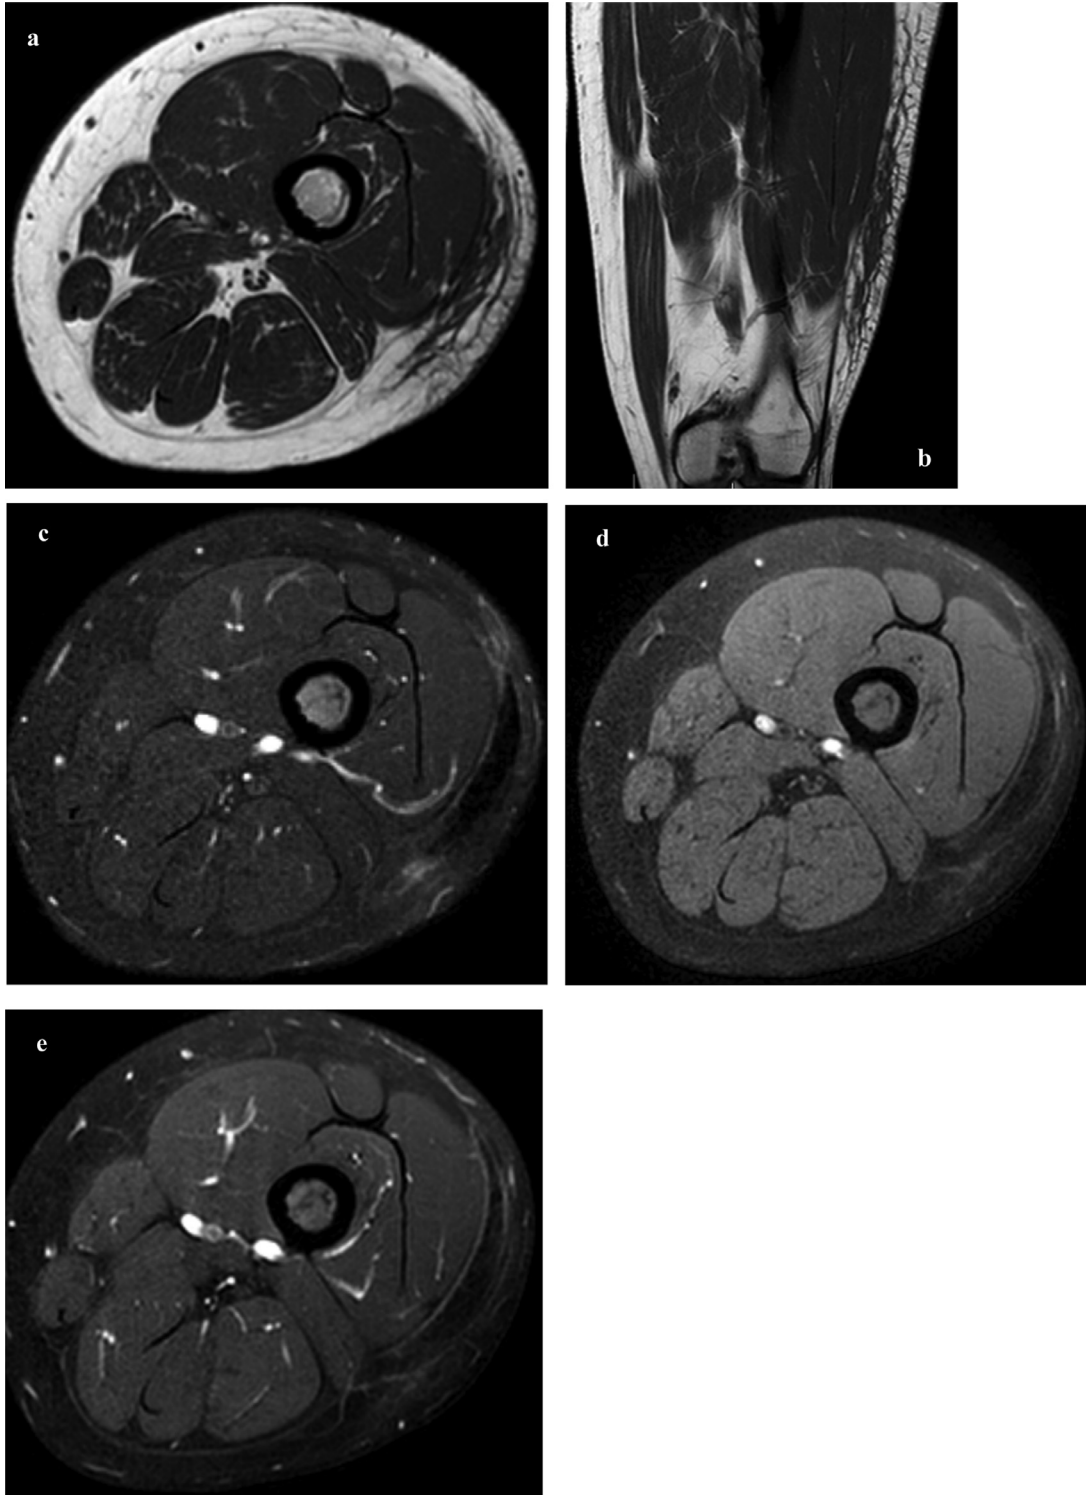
MR images of the distal left thigh. (a) Axial and (b) coronal T1W TSE, (c) fat-suppressed axial T2W FSE, fat-suppressed axial T1W (d) pre- and (e) post-contrast. Images show an elliptical-shaped area of iso-to-hypointense signal on both T1- and T2-weighted images in the subcutaneous fat at the distal lateral thigh with no significant enhancement and with mild surrounding subcutaneous edema.
